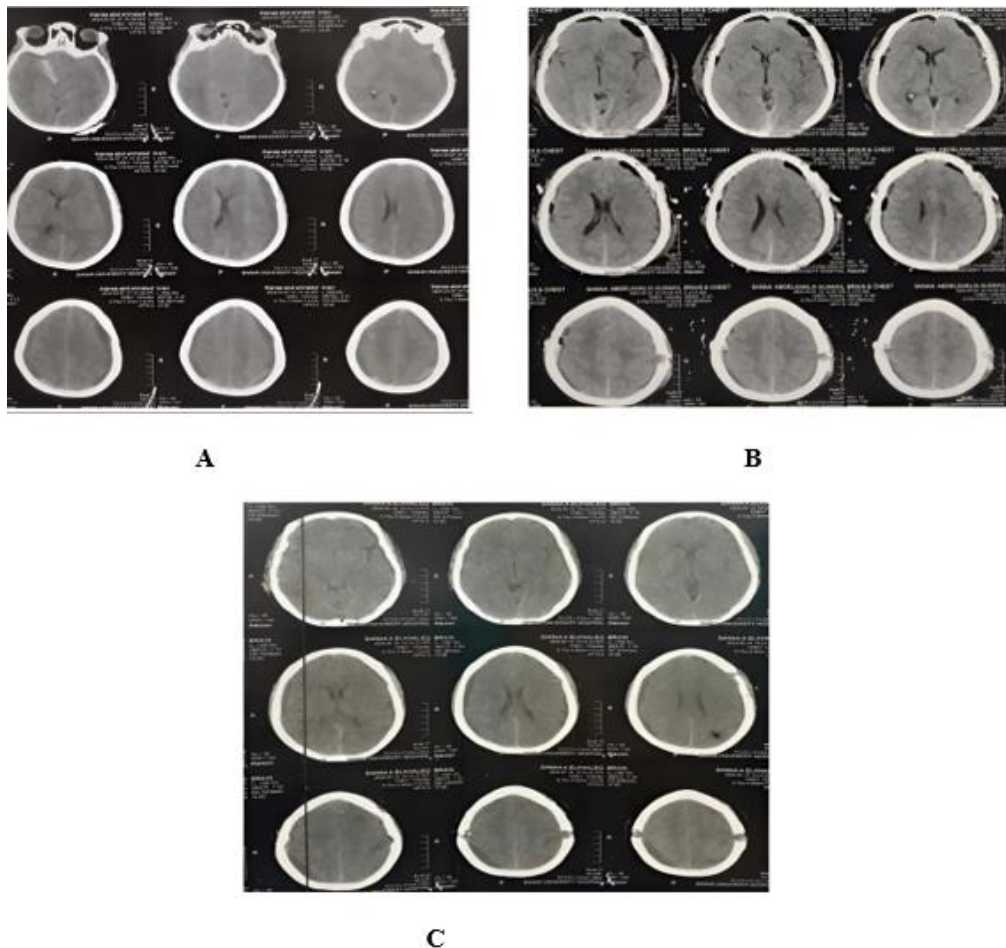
(A) CT brain axial view showing bilateral tempo-parietal sub-acute SDH, (B) Immediate Post-operative CT Brain axial view showing good evacuated hematoma with accepted decompression, (C) CT Brain axial view FU after 1 month of surgery accepted evacuated hematoma.
